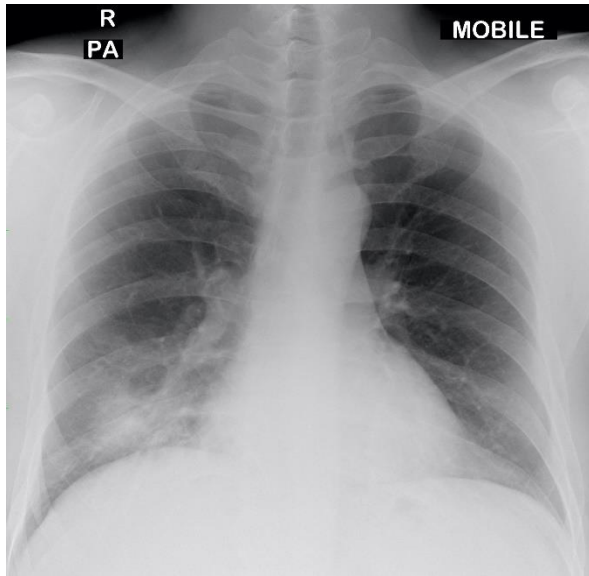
A 35-year-old man with fever and cough for one day. Chest radiograph obtained at Day 1 of symptoms shows a unifocal consolidation in the right lower zone, predominantly in the infrahilar location.
